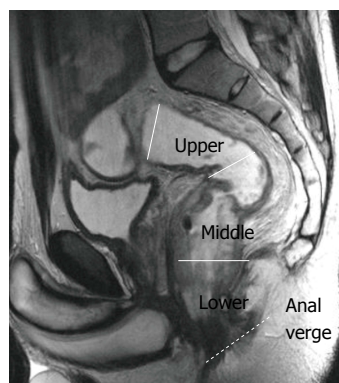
Rectal segments. T2-weighted sagittal image shows rectal segments: Lower, < 5 cm; middle, 5-10 cm; upper, > 10 cm from the anal verge.
